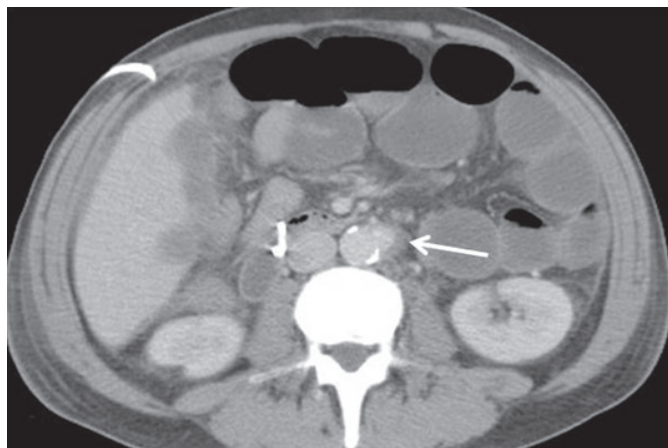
CT scan of the abdomen with contrast IV in portal phase and axial cut, identifying aortic wall calcifications and a left lateral wall saccular aneurysm of infrarenal abdominal aorta of 35 mm maximum axial diameter with mural thrombus, subhepatic hypodense collection and dilation of small intestine loops.
